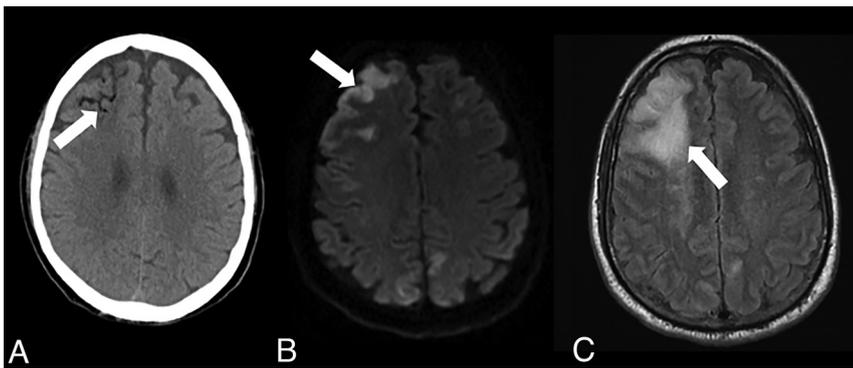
A 64-year-old man with suspected CAE. A noncontrast brain CT reveals extra-axial gas in the right frontal lobe (*white arrow*, A). Non-contrast-enhanced brain MRI demonstrates a mixed pattern of cytotoxic (*white arrow*, DWI sequence, B) and vasogenic edema (*white arrow*, T2-FLAIR sequence, C) in the bilateral right-greater-than-left MCA-ACA borderzones. Findings were consistent with CAE stemming from intravascular introduction of gas along the cavity of patient's chest wall during wound packing.
